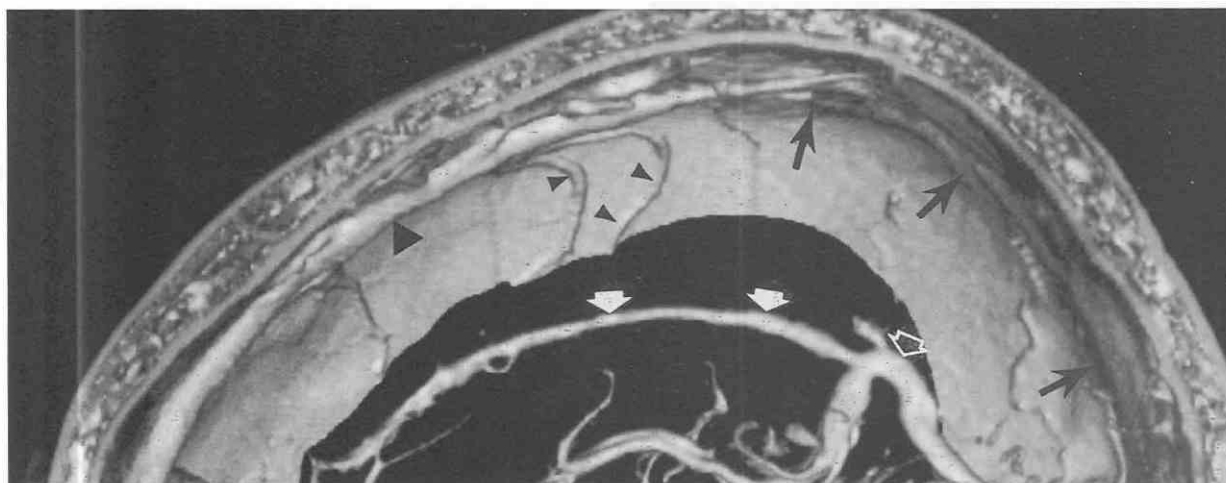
Superior sagittal sinus thrombosis. Surface-rendered CT venogram study shows absent opacification in the posterior portion of the superior sagittal sinus (*black arrows*). The anterior portion of the superior sagittal sinus is patent (*triangle*). Small cortical veins are depicted (*arrowheads*). The inferior sagittal sinus (*small arrows*) and the vein of Galen are also seen (*open arrow*).
